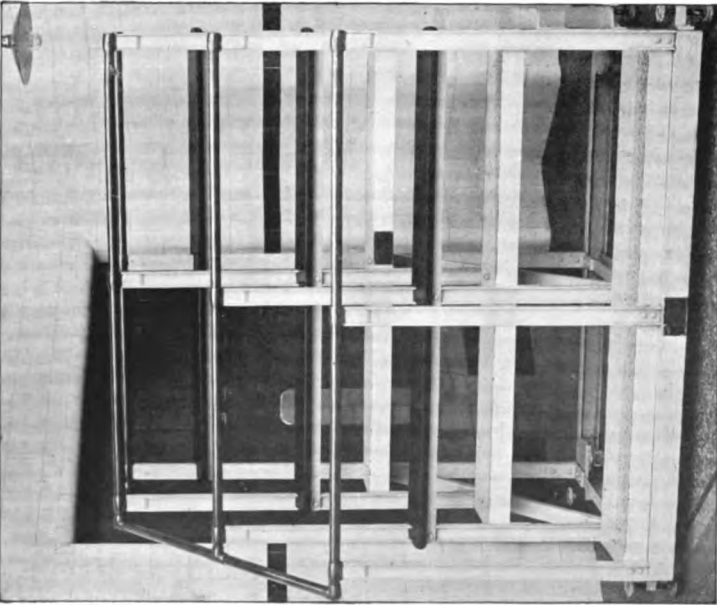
MOVABLE SPECTATORS' GALLERY.
